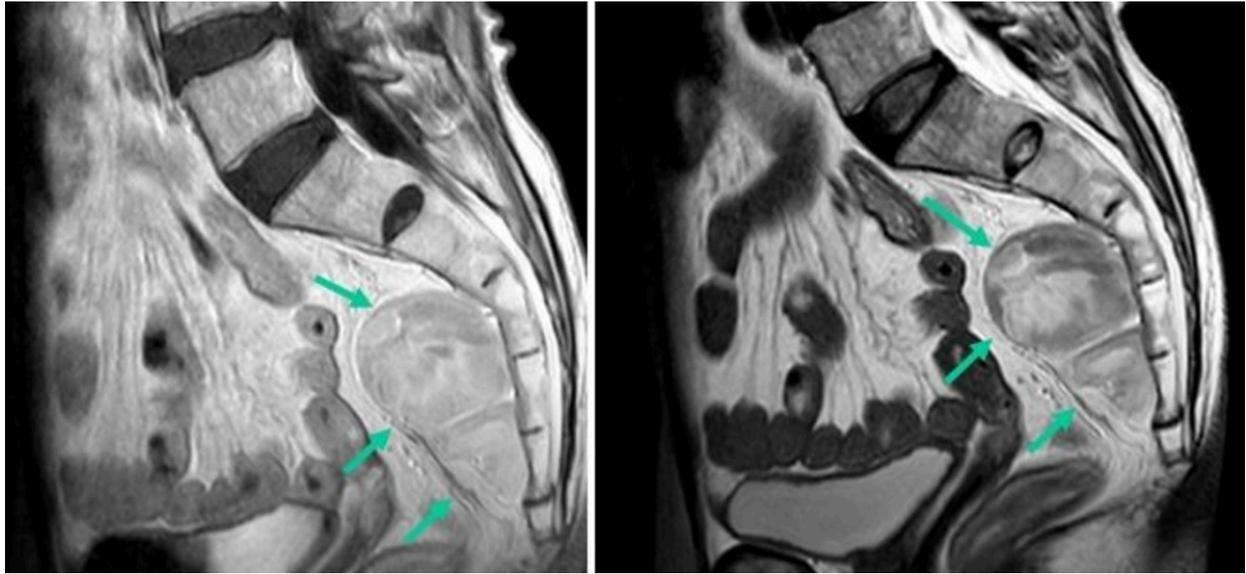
Presacral extra-adrenal myelolipoma. Pre-contrast T1 and T2-weighted fast spin echo (FSE) sagittal image at the level of the midsacrum demonstrated a lobulated presacral mass with mixed fat/soft tissue signal (arrows). No bony invasion was seen.
